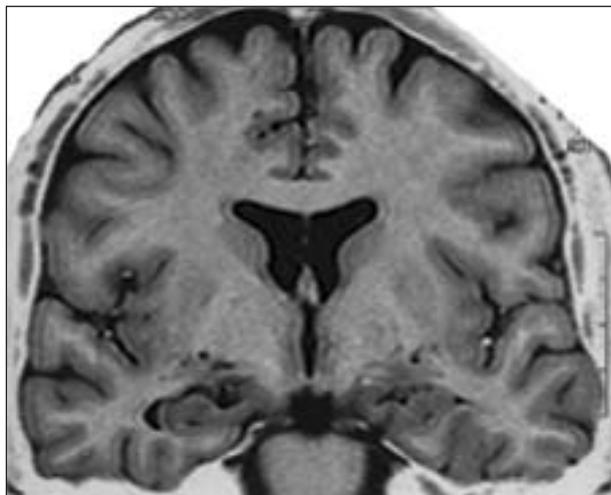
Inverted T2-weighted brain MRI. Cortical thickening on left collateral sulcus and ipsilateral fusiform gyrus is documented.
